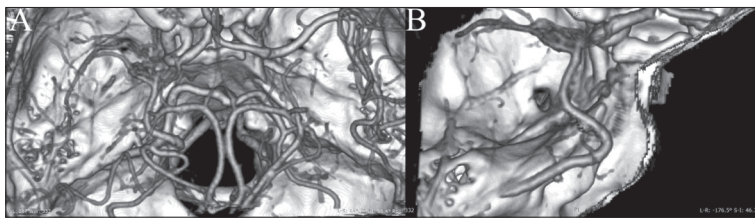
Computed tomography angiography volume rendering; A and B show deep middle cerebral veins anomalous drainage into superior petrosal sinus
